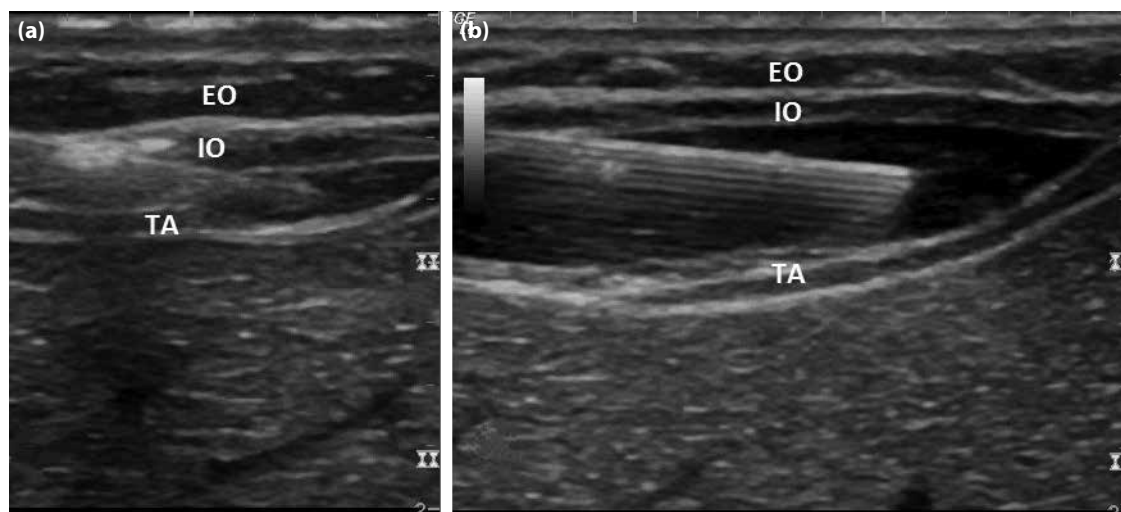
(a) Ultrasonography of anterior abdominal wall during initial needle insertion. (b) Ultrasonography of anterior abdominal wall when injectate separates internal oblique and transversus abdominis muscle. EO: External oblique muscle; IO: Internal oblique muscle; TA: Transversus abdominis muscle.
